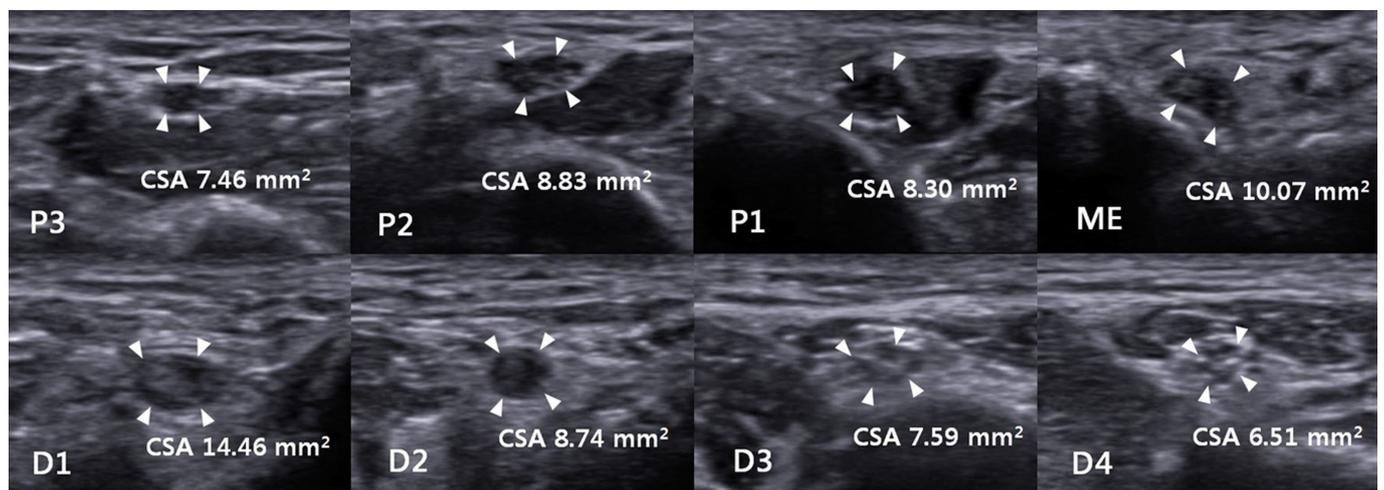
Ultrasound image of the ulnar nerve in a patient without diabetic polyneuropathy, but with subclinical ulnar neuropathy at the elbow (UNE_e group) at 8 stimulation sites, including 3 sites proximal (P3, P2, and P1) to the medial epicondyle (ME), ME, and 4 sites distal (D1, D2, D3, and D4) to the ME. The maximum cross-sectional area (CSA) was observed 1 cm distal (D1) to the ME.
